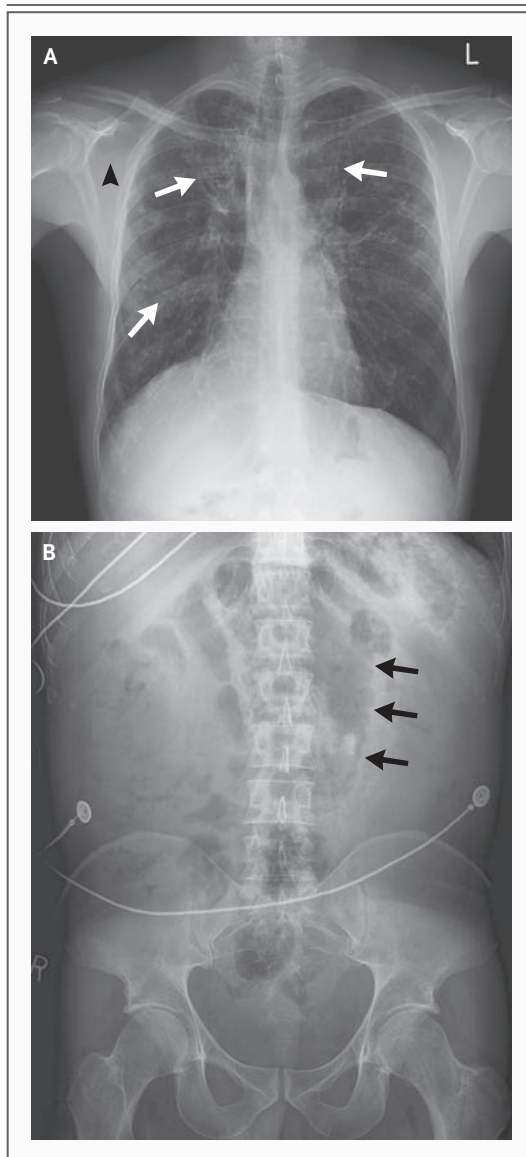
Chest and Abdominal Radiographs.
